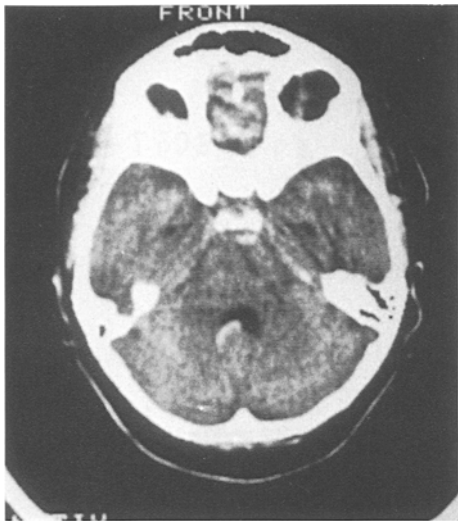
CT scan shows moderate bleeding in the 4th ventricle and the prepontine cistern
